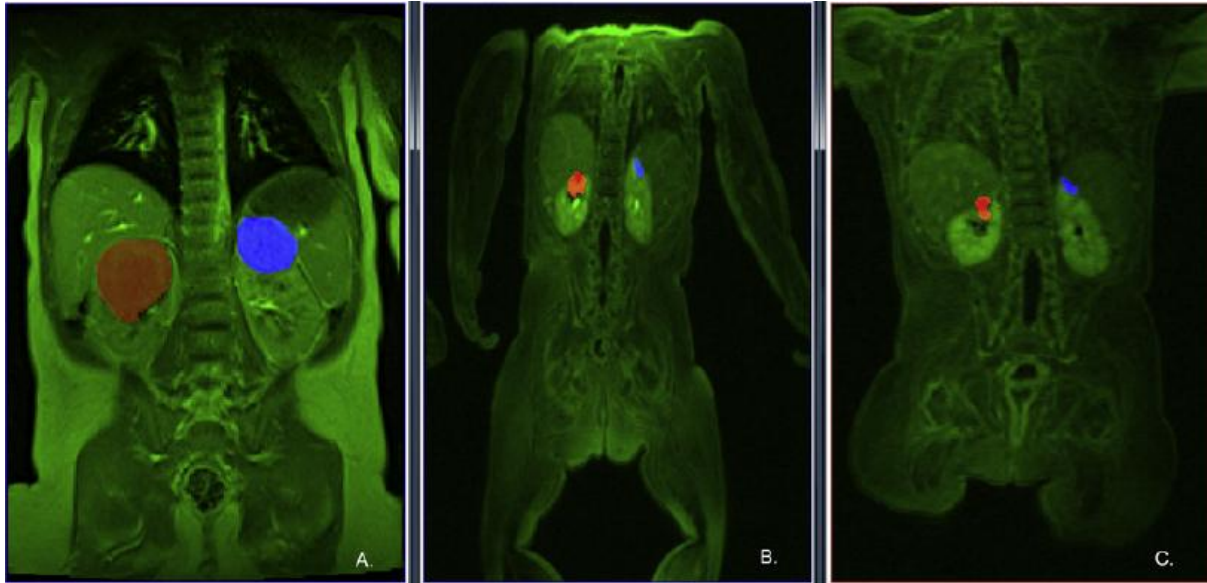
Imaging data of the bilateral nephroblastomatosis case modeled. Representative MRI images merged with the tumor annotations of the right (red) and left (blue) kidney at three time instants: (A) Time of diagnosis ($t/40$ day). (B) An intermediate point during chemotherapy ($t/475$ day). (C) After the completion of chemotherapy ($t/4108$ day,). The images have been produced with ImageJ [36].
